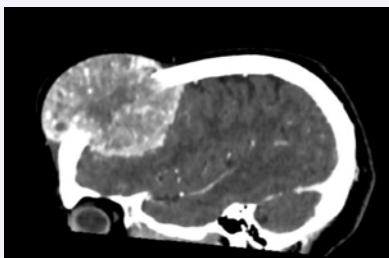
Sagittal brain CT.
